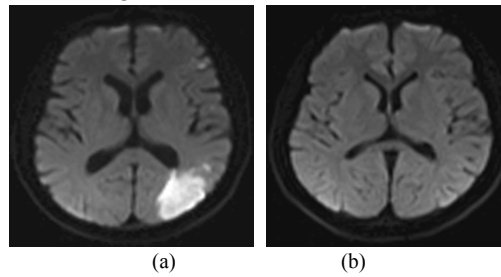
(a) Axial DW MRI showing infarct in area 6
